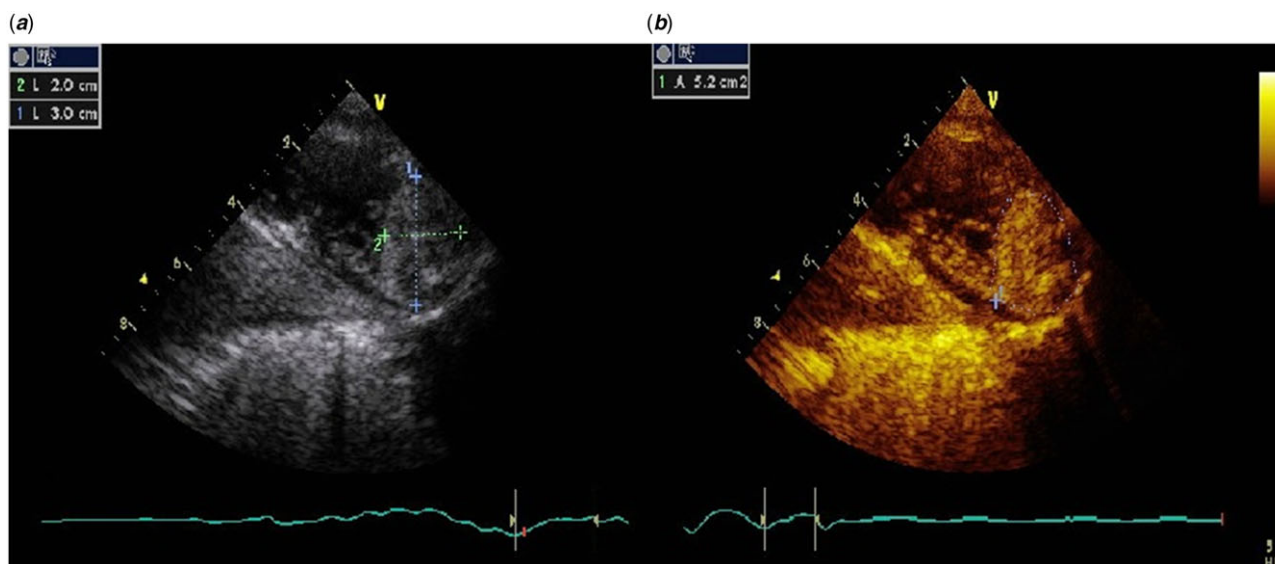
(a) 2D transthoracic echocardiographic examination demonstrated a 20 mm × 30 mm sized mass at the left ventricle apex myocardium. (b) Three-dimensional transthoracic echocardiography demonstrated that egg-shaped mass measuring 2.3 by 2.8 cm along the apical portion of lateral wall.
